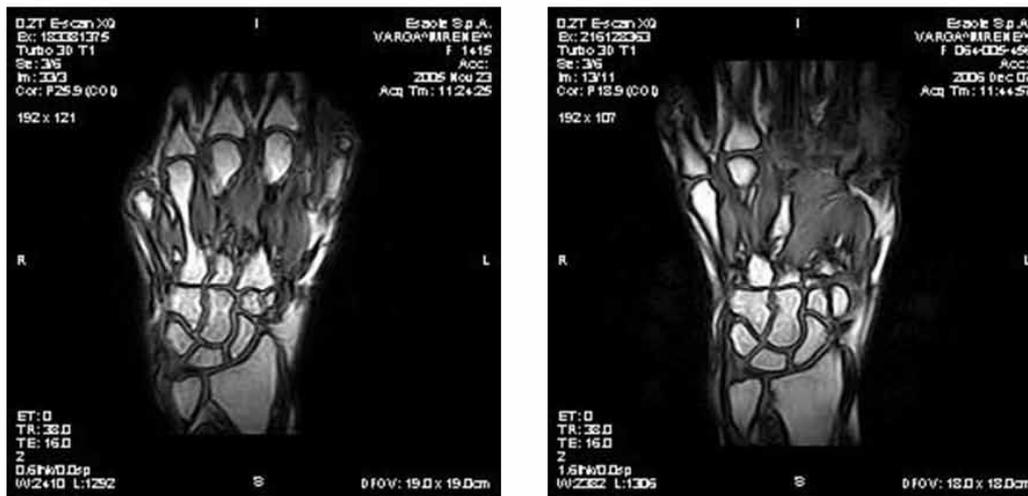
3D T1-weighted MRI images of the region from the radiocarpal to the MCP joints of the same patient. Left: No erosions are visible on this baseline scan. Right: On this image obtained 13 months later, erosions are depicted on the lateral-radial surface of the distal radioulnar joint.
